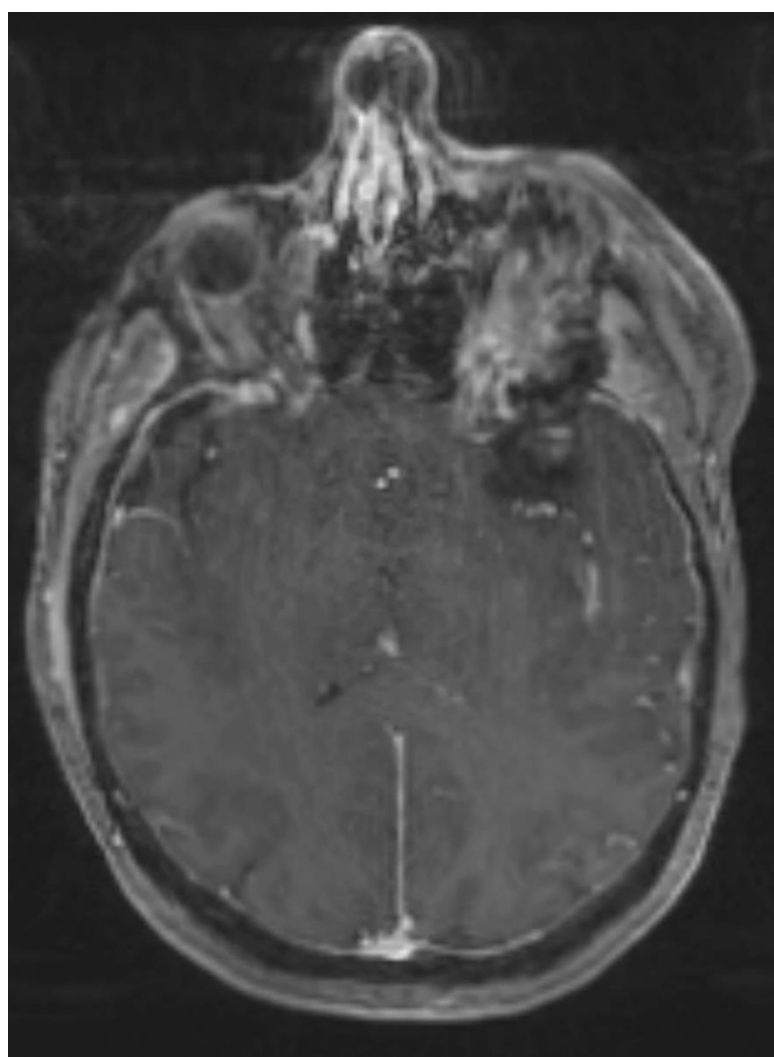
Immediate postop axial T1 post-contrast MRI
